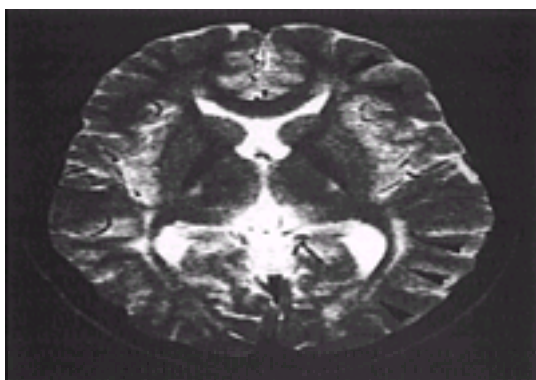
T2-weighted magnetic resonance imaging of a 16-year-old girl with phenylketonuria. The scan was performed at 16 years of age. At the time of the scan, her neurologic examination was normal, but her phenylalanine level was high. The hyperintense signal, particularly in the parieto-occipital areas, but also at the tips of the anterior horns of the lateral ventricles, is characteristic of phenylketonuria. (From the Neurorehabilitation Section, Institute of Neurology, University of London.)
